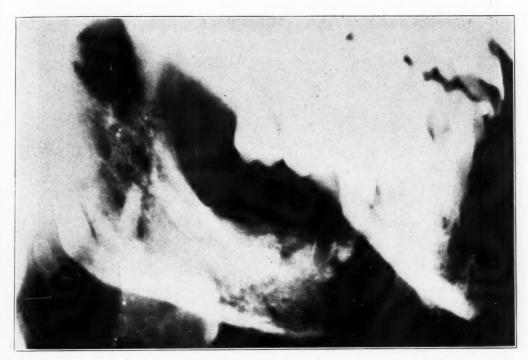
Roentgenogram of mandible showing acute osteomyelitis, Fig. 10.
